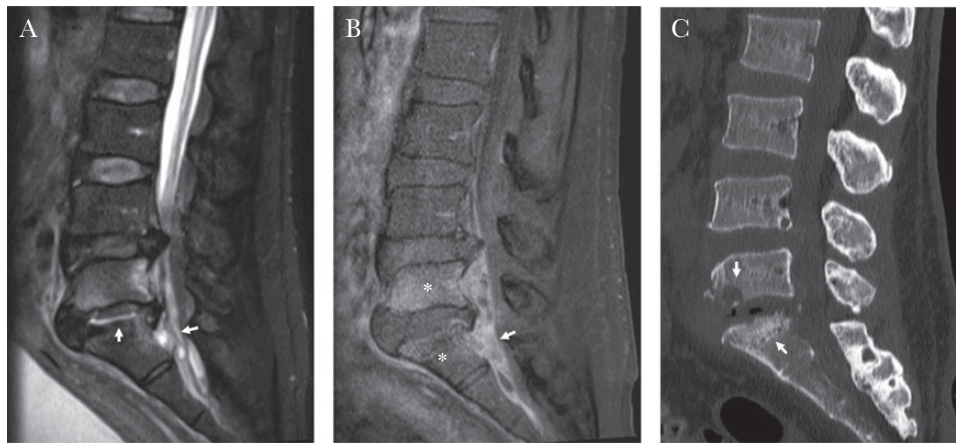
Magnetic resonance imaging (MRI) and computed tomographic (CT) scan examinations before antibiotic therapy. *A* and *B*, T2 (*A*) and injected T1 (*B*) weighted MRI examination of the spine, showing L5–S1 infectious spondylitis with an intervertebral abscess (T2-hyperintense centimetric lesion [fluid] in the L5–S1 disk with gadolinium enhancement in periphery, vertical arrow in *A*) and epidural abscesses (infracentimetric collections in the anterior and posterior epidural space stretching from L5 to S2 and responsible for a spinal stenosis, horizontal arrow in *A* and *B*). Note the enhanced signal in L5 and S1 vertebral bone after gadolinium injection (asterisks, *B*). *C*, CT examination shows bone erosions of vertebral endplates (arrows).
